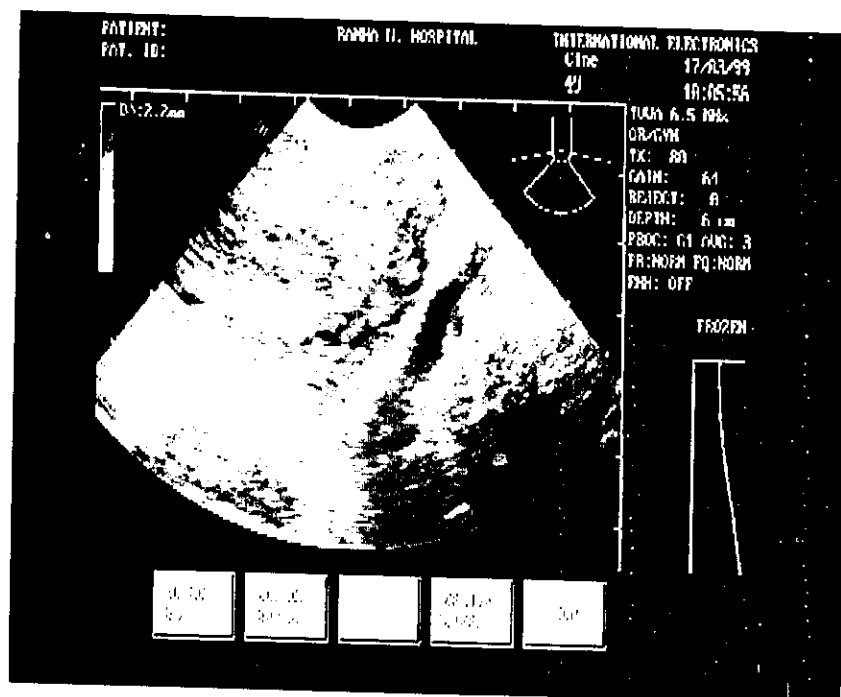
Shows sonographic picture of atrophic endometrium.
